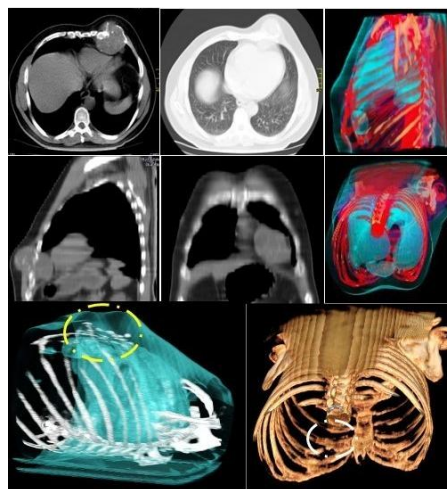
Chest CT scan shows an oval lesion (circle) with osteolytic cortical bone destruction of the VII rib (110 mm x 100 mm x 59 mm in size). The margins were poorly defined with some ossifying matrix and no evidence of extension to the adjacent soft tissue. Axial, coronal, and sagittal sections. 3D reconstruction. CT scan.
